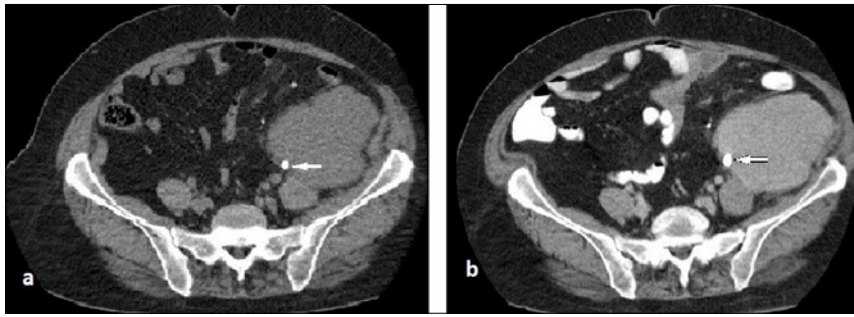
A. A mass lesion including a calcific component in close proximity with the psoas muscle in axial pre- (B) and post-contrast CT images.
